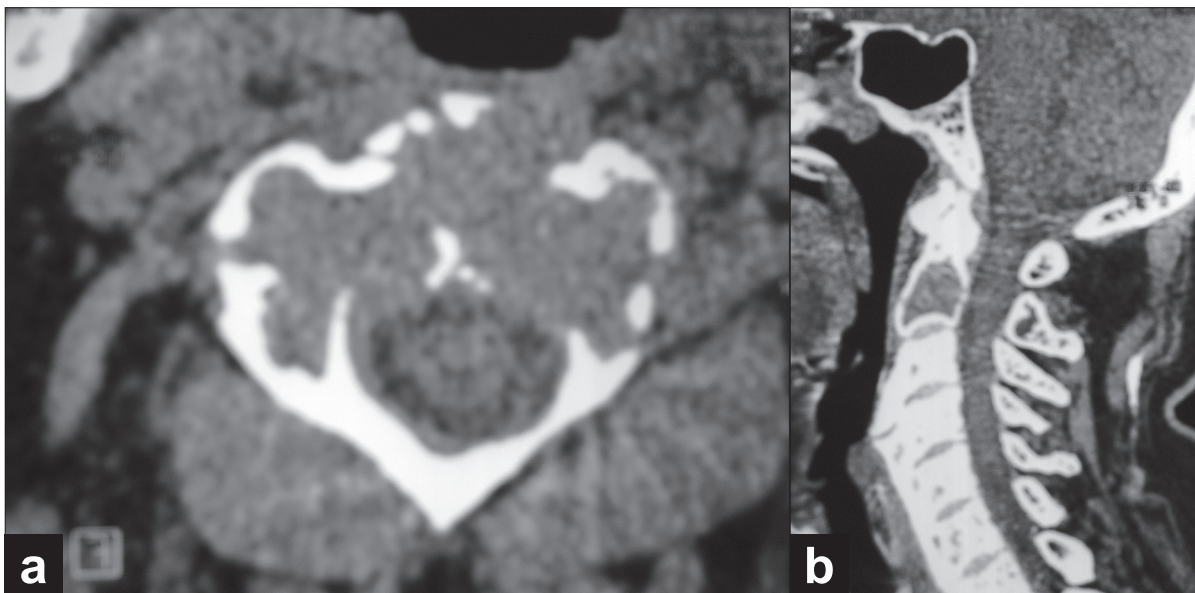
Computed tomography scan of the cervical spine (a; transverse cut, b; sagittal cut) showing fibrous dysplasia axis (ground-glass appearance)
